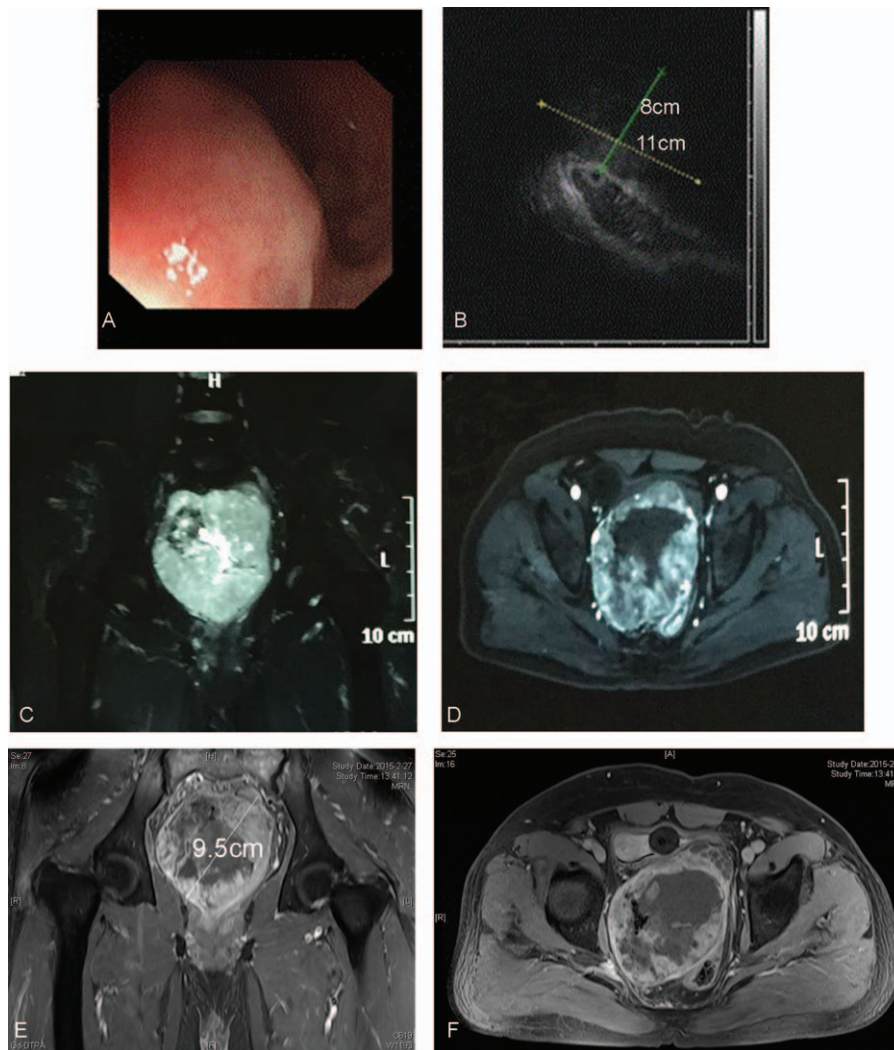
Preoperative examinations. (A) Enteroscopy analysis, (B) ultrasound analysis during the enteroscopy, (C and D) magnetic resonance imaging (MRI) analysis before the use of imatinib therapy, and (E and F) MRI analysis after the use of imatinib therapy with the 3-month period.
